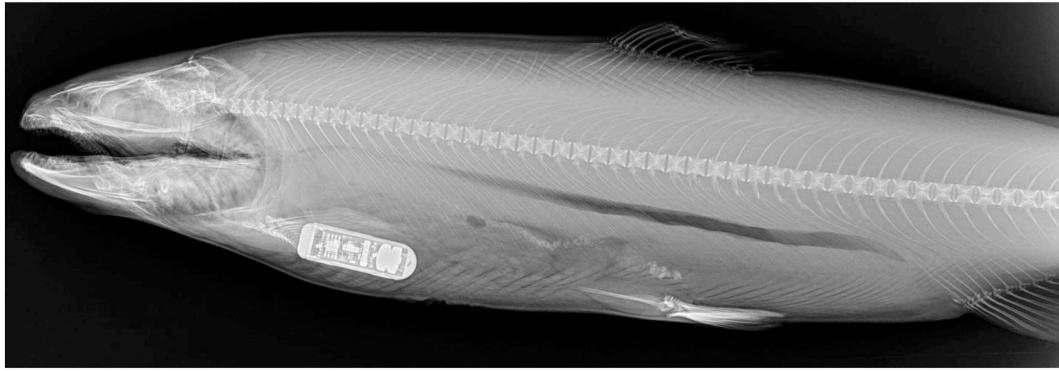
X-ray photograph of a tagged fish: The placement of the bio-logger in close proximity of the pericardium can be seen. The X-ray was taken at the end of the experiment to confirm that the bio-logger still was positioned adequately inside the fish. Moreover, it can be seen that the side with two electrodes is oriented ventrally and the side with one electrode is oriented dorsally.
